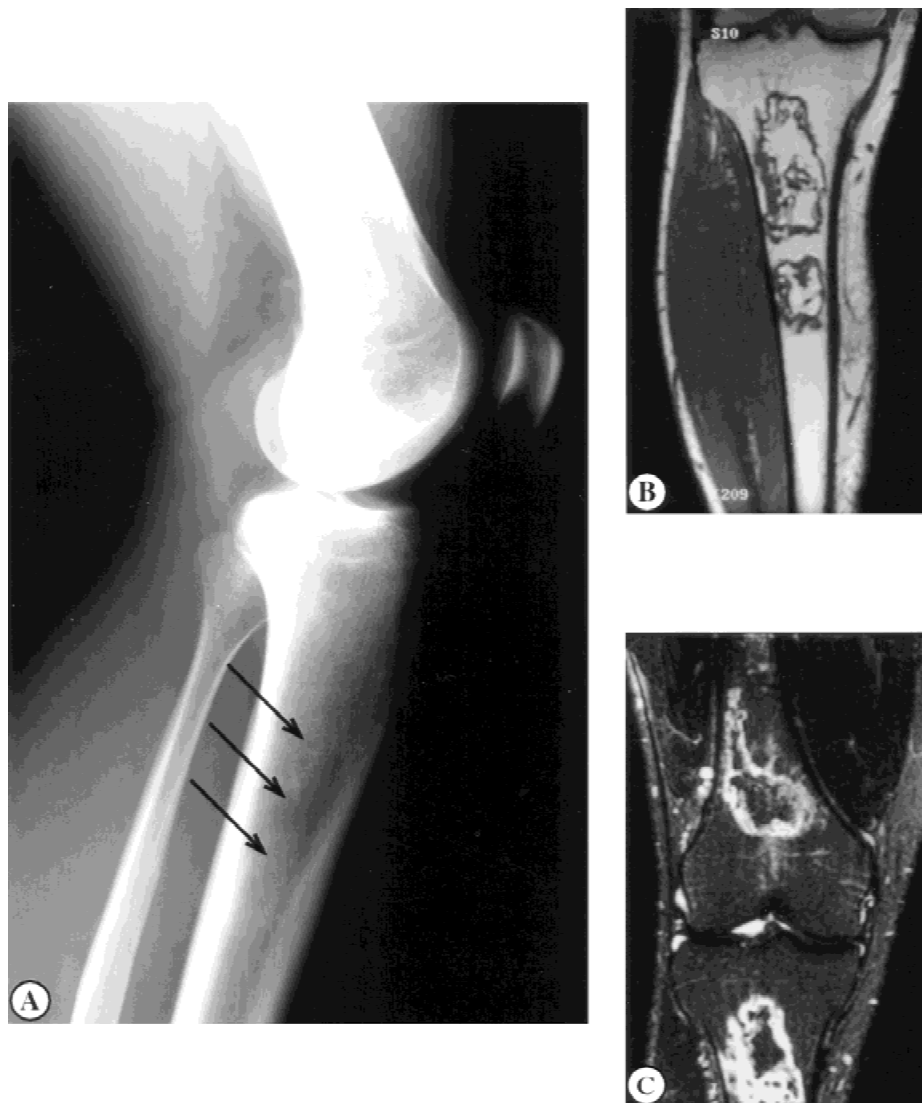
Multiple infarcts of the distal femur and proximal tibia of patient UN-2. The plain film (A) shows lytic changes (arrows) incorrectly interpreted to be recurrent lymphoma. T1-weighted spin echo MR images (B) show serpiginous lesions with low signal intensity borders characteristic of bone infarcts. On T2-weighted fat suppressed images (C), the borders of the lesions demonstrate high signal intensity compared to the adjacent marrow.
